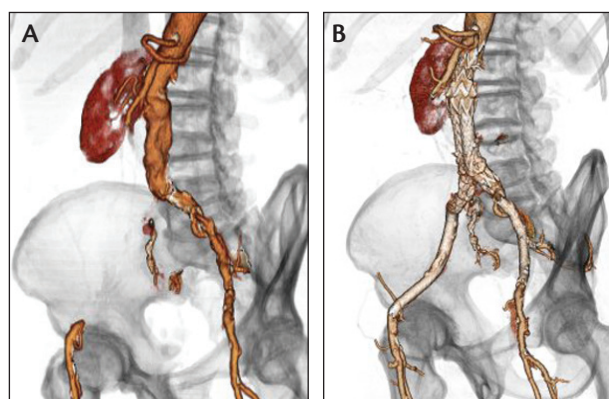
Pre- (A) and postoperative (B) CT angiograms of an AAA associated with right common and external iliac artery occlusion and severe stenosis of the left external iliac artery treated with INCRAFT® Stent Graft System implantation and self-expanding stenting of the access vessels.
